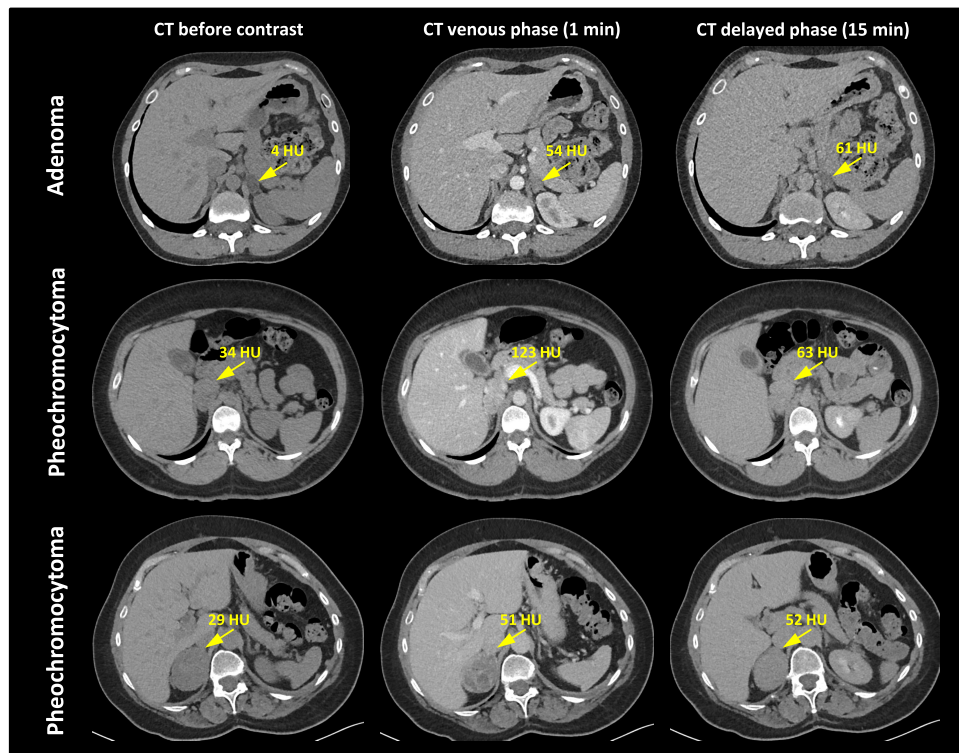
CT of PCC vs adenoma. CT images of a patient with left adrenal adenoma with low precontrast attenuation and lack of contrast washout (upper panels); a patient with right PCC with high postcontrast attenuation (123 HU) and high absolute (67%) and relative (49%) contrast washout (middle panels); a patient with right PCC displaying lack of contrast washout (lower panels). The adrenal lesions are marked by arrows. Abbreviations: CT, computed tomography; HU, Hounsfield units.
